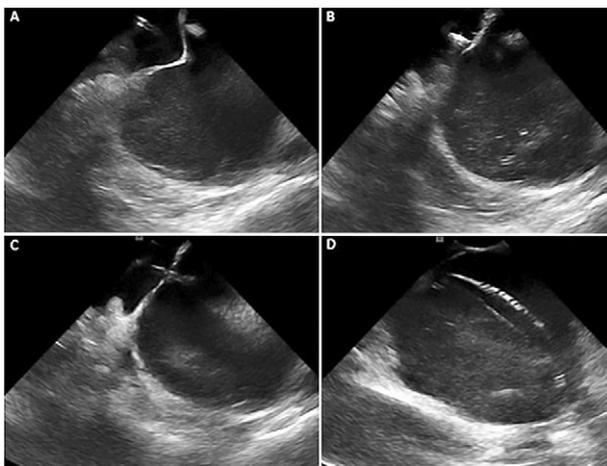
Intracardiac echocardiography guidance of transseptal puncture and catheter positioning. A. Tenting of interatrial septum showing the right needle position. B and C. Transseptal puncture. D. Catheter placement in the left inferior pulmonary vein.
